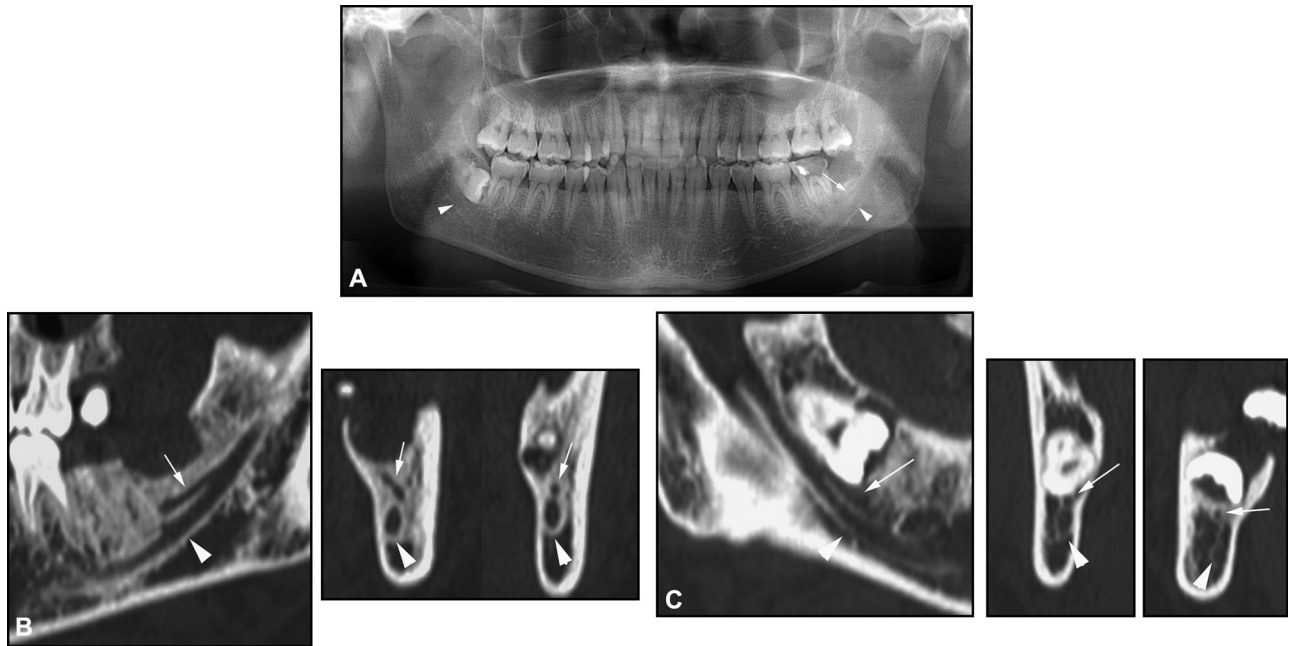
Radiographs of patient 1. A, Panoramic image. B, Reconstructed CT image in the left side. C, Reconstructed CT image in right side. The left bifid mandibular canal was suggested on the panoramic image. In the left mandible, there was a single mandibular foramen, and the upper canal narrowed toward the distal area of the second molar after the bifurcation on the reconstructed CT images. In addition, in the right mandible, there was a single mandibular foramen, and the upper canal narrowed along the third molar after the bifurcation on the reconstructed CT images.
